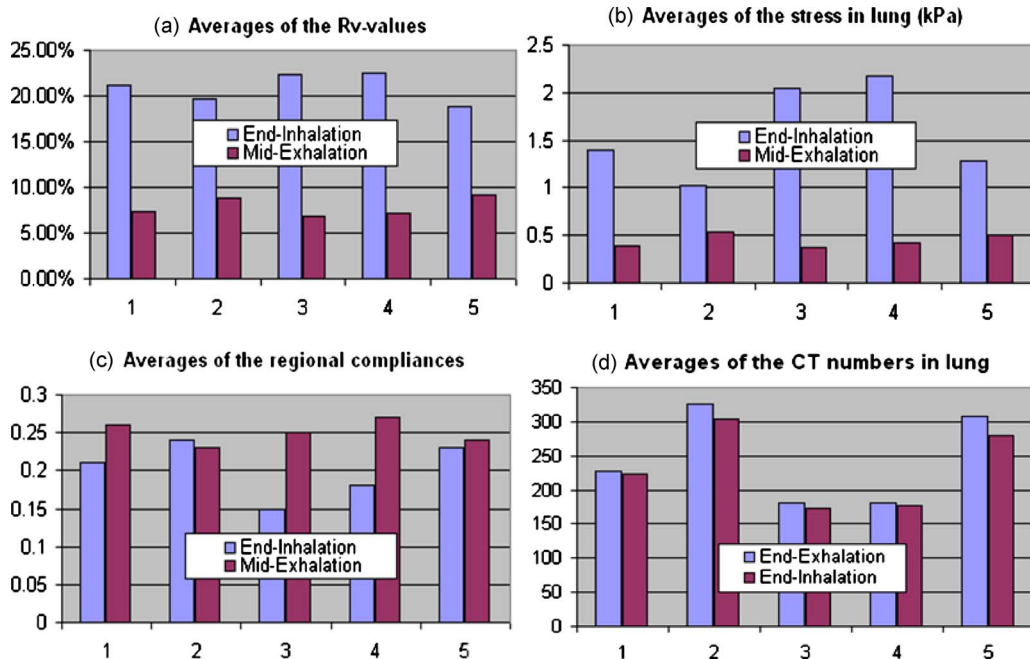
The ventilation and compliance measured from the 4DCT images of the five patients treated in HFHS: (a) The average  $R_v$  values, (b) the average stresses, (c) the average regional compliances, and (d) the average CT numbers in the lung.
